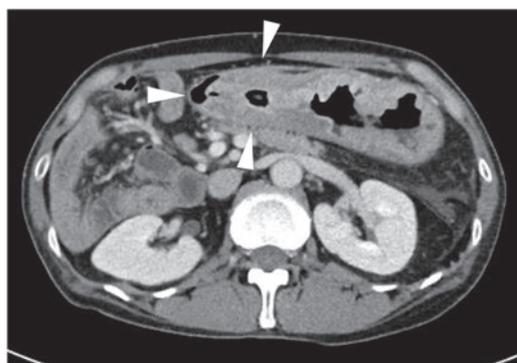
Computed tomography (CT) scan findings after induction chemotherapy.
